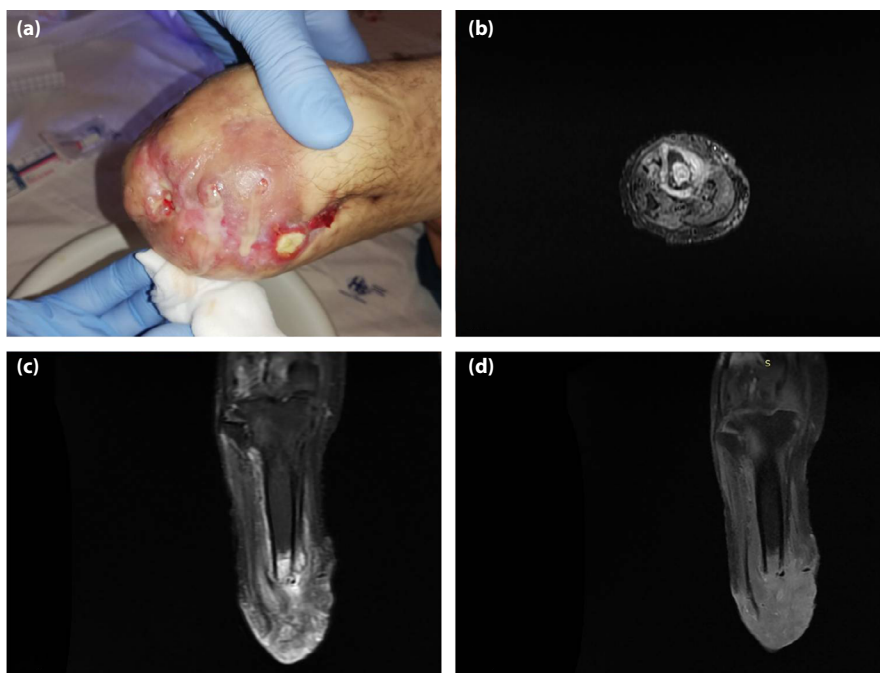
(a) Clinical signs of infection of the patient's residual limb during hospitalization (phlogosis and purulent discharge after light pressure). (b,c) Hyperintense signal of the tibia and the soft tissues in axial and coronal short tau inversion recovery magnetic resonance imaging sequences. (d) Contrast impregnation of the tibia and the soft tissues in coronal T1-weighted Fat suppressed (FS) sequence after gadolinium administration.
